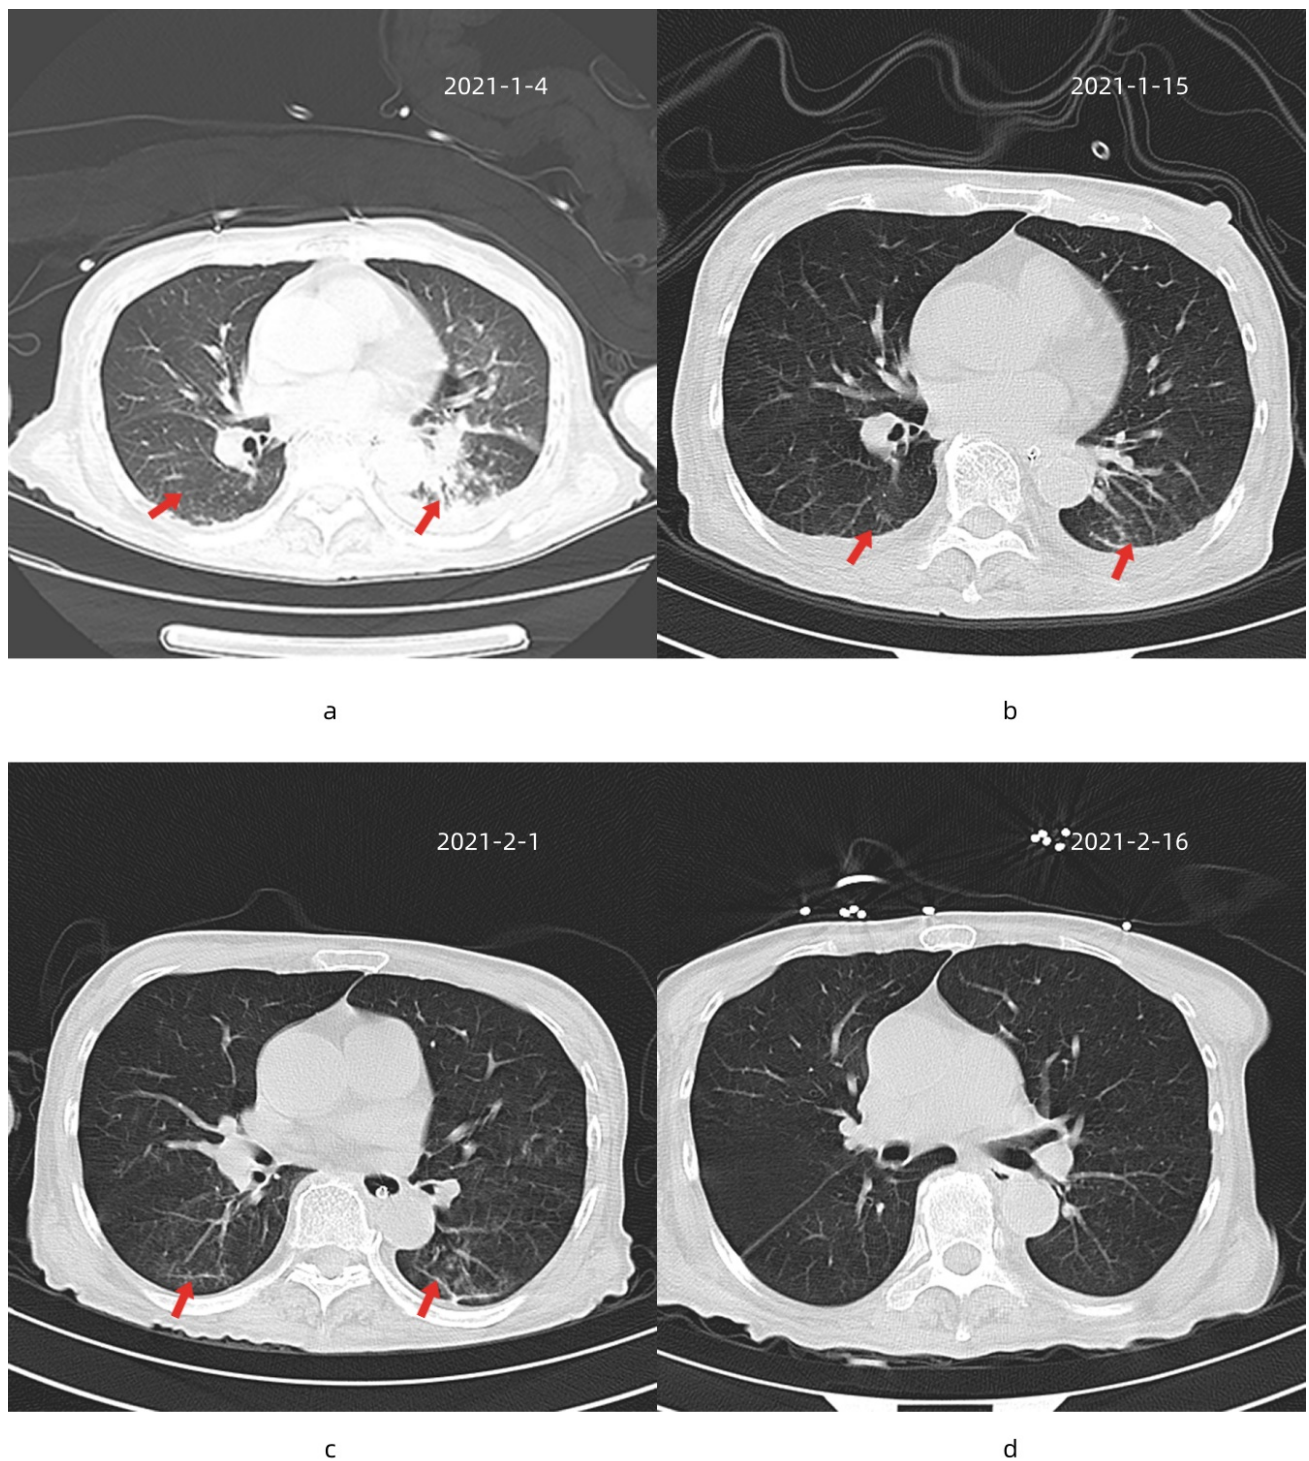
The evolution process of inflammatory lesions shown in the patient's chest computed tomography (CT) scan. Chest CT images were scanned on January 4, 2021 (a), January 15, 2021 (b), February 1, 2021 (c), and February 16, 2021 (d) respectively, with arrows indicating the areas of inflammation in the lung. (a) was taken when the patient was admitted to the emergency department due to shortness of breath and fever, revealing severe inflammatory infiltration over several lobes. (b) showed that the pneumonia had improved four days after her transfer to our psychiatric hospital. However, the situation shown in (c) deteriorated due to the patient's unimproved symptoms of catatonia, along with persistent aspiration. Finally, inflammation in the lungs was relieved in (d) after eight sessions of modified electroconvulsive therapy (mECT) treatment, and she recovered from catatonia.
